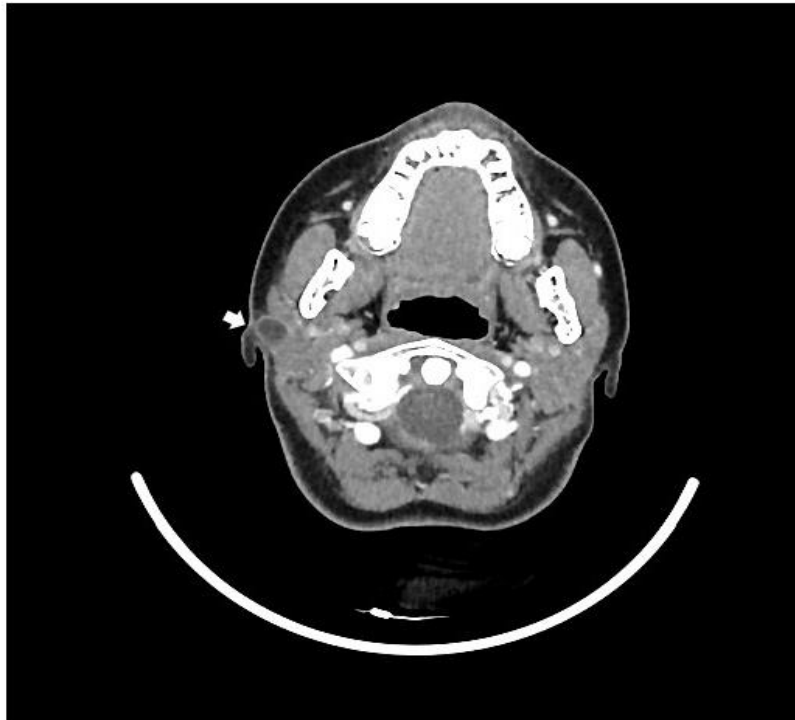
Axial view of contrast enhanced CT Neck showed a rim enhancing hypodense lesion (white arrow) at right postero- inferior auricular region measuring 1.3x0.8x1.4cm with fistula communication to the skin. The lesion was indenting on the superficial lobe of right parotid gland but there was no abnormal enhancement of right parotid gland.
